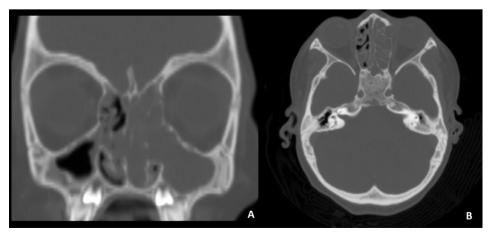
A CT scan was performed at that time, confirming left-sided inflammatory disease.
